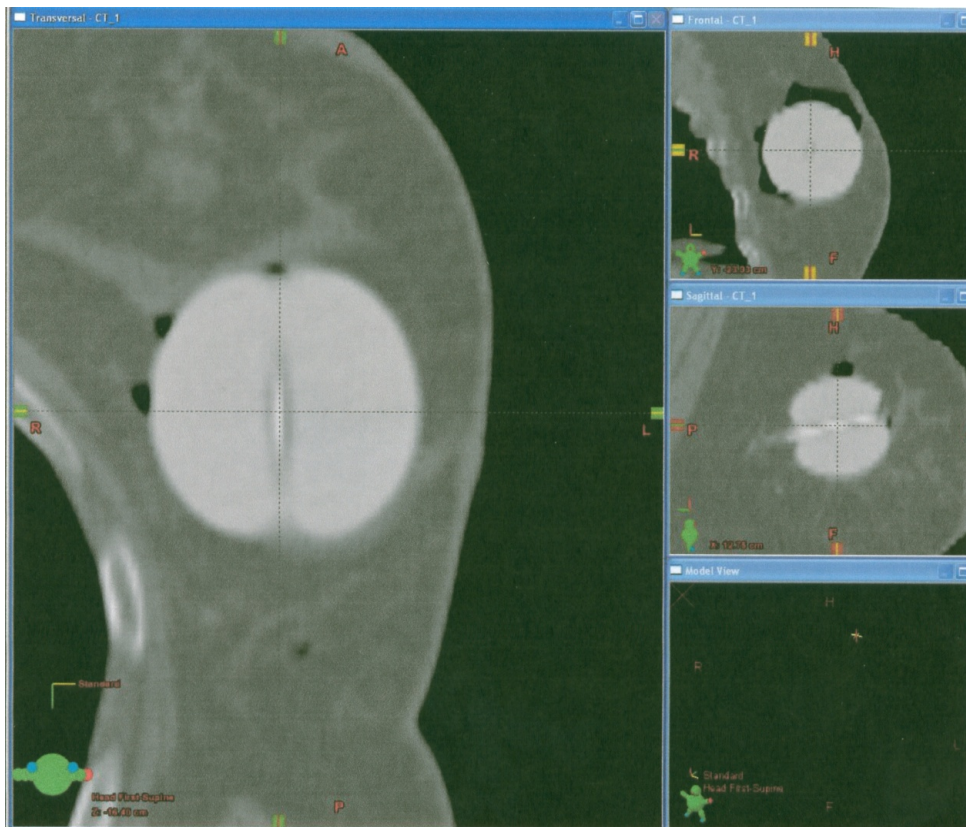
The central radiographic marker (dummy source) is used to determine the central location of the single dwell source MammoSite RTS.
